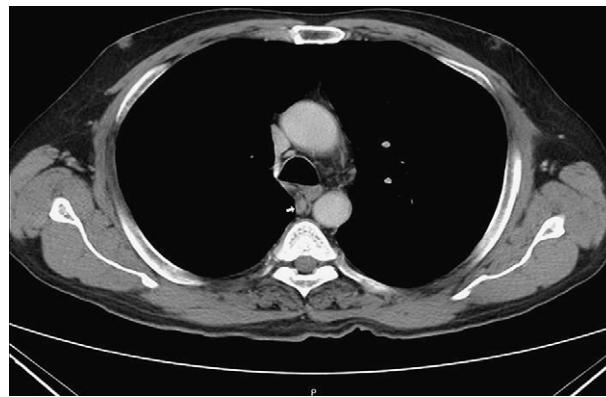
Contrast enhanced axial plane of CT scan of chest showing the normal location of azygos vein at tracheobronchial angle (Single white arrow).
